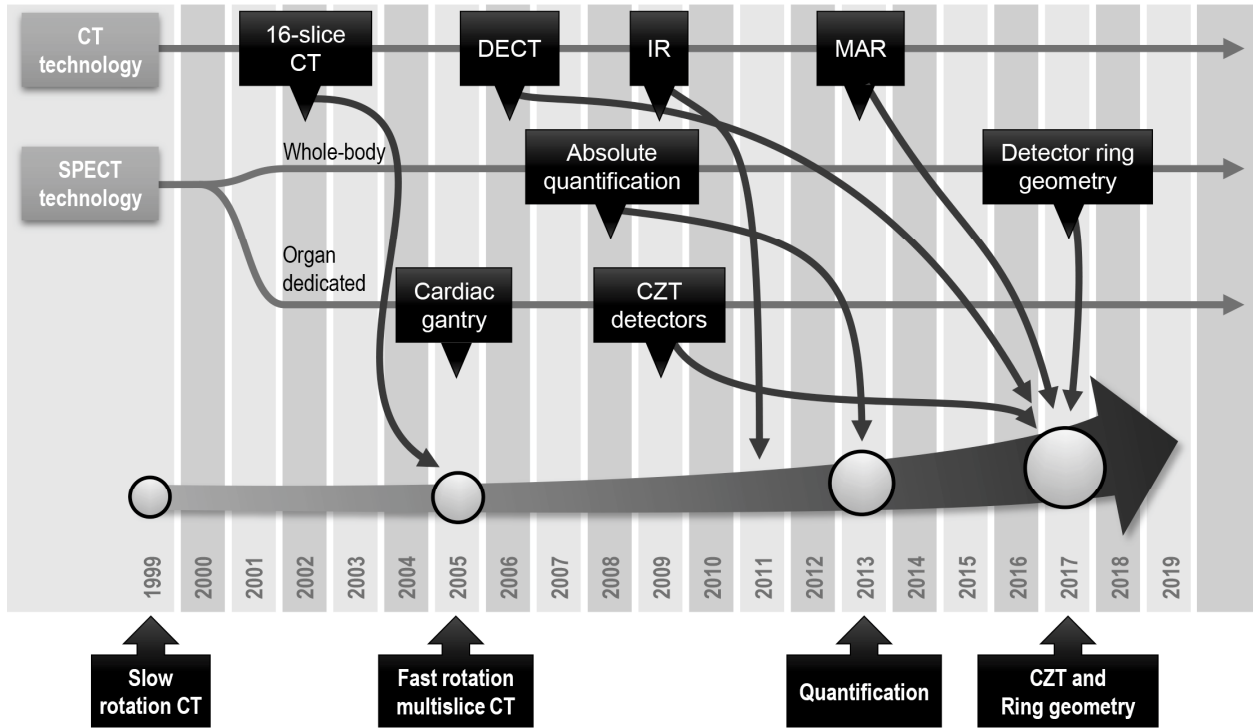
Summary of approximate time of introduction of milestones in whole-body SPECT/CT technology, showing incorporation of subsequent innovations in CT and SPECT technology. While some novel CT technologies were quickly incorporated into SPECT/CT systems (e.g. iterative reconstruction), others showed significant delays in their translation into hybrid scanners. For SPECT innovations, it is interesting to note the parallel development of dedicated cardiac gantry designs that saw earlier introduction of breakthroughs, such as CZT detectors, compared to whole-body capable devices.
